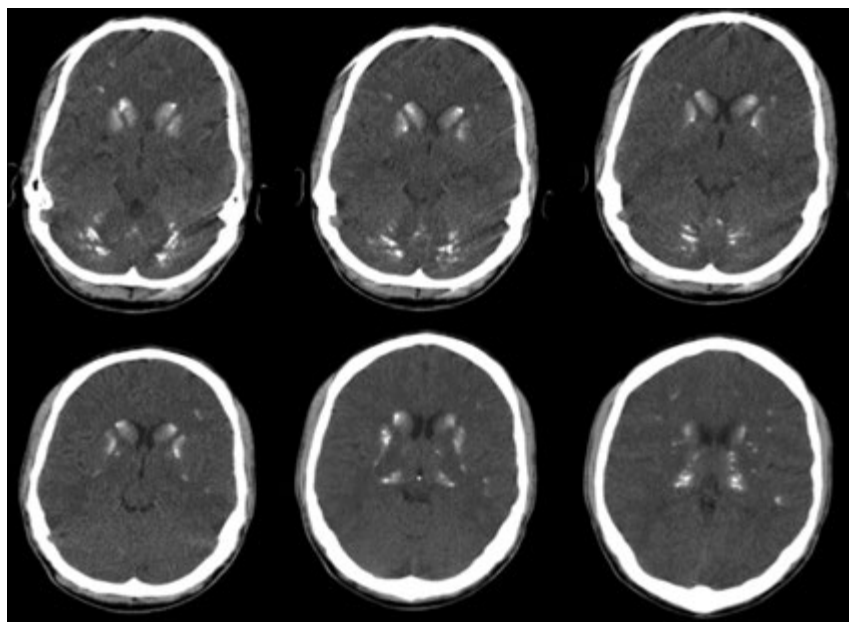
Cerebral CT scan revealing extensive bilateral and symmetrical calcification in the basal ganglia, thalamus and subcortical cerebral white matter.
